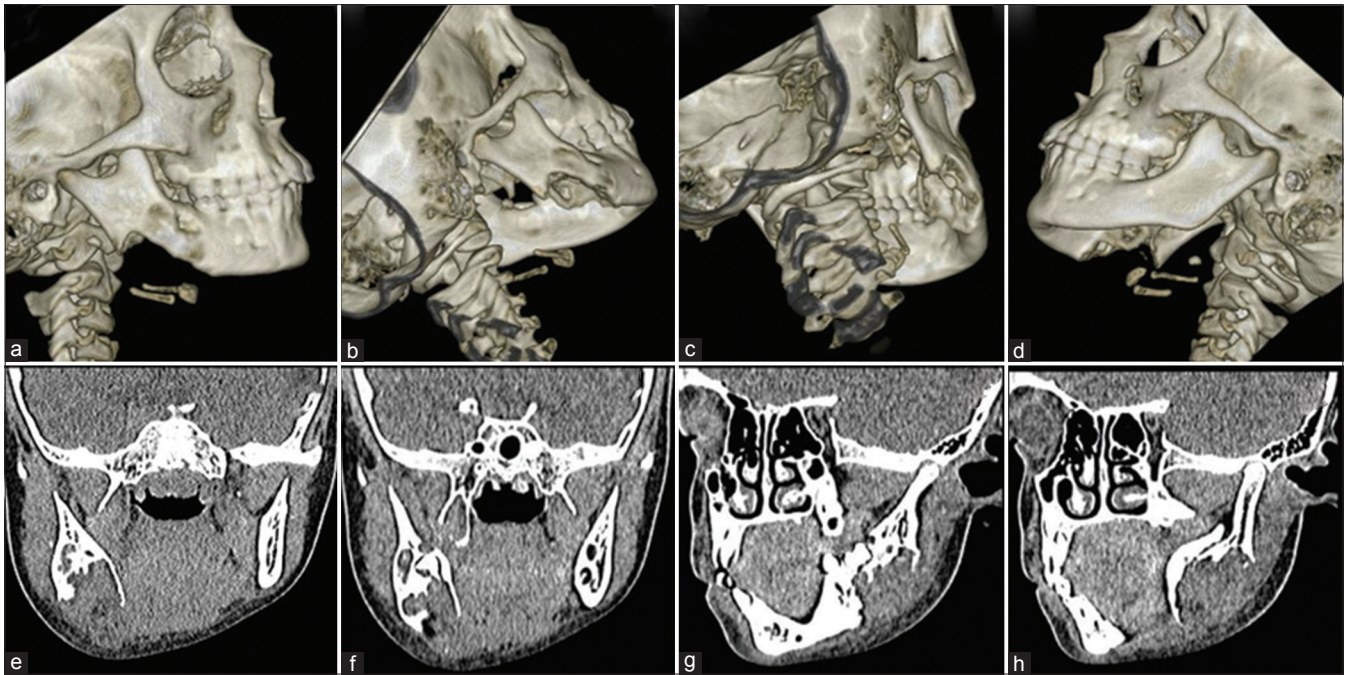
(a-h) Postoperative non contrast computed tomographic revealed smooth residual margins, walls, and floor of residual bony defect
